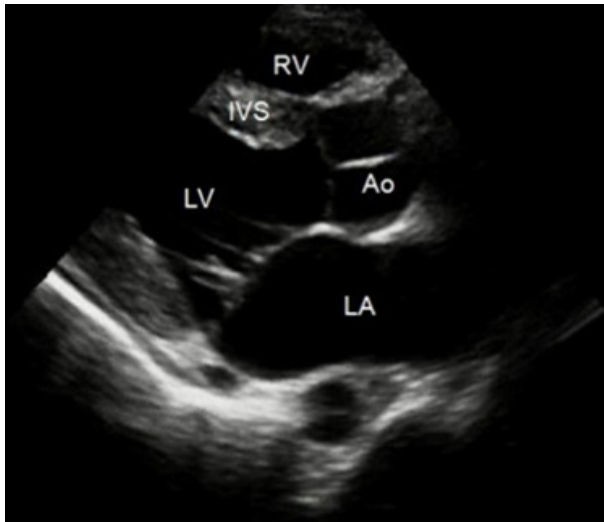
Post-chemotherapy transthoracic echocardiography in comparative view showed a markedly decrease in leukemic infiltration in all previous lesions.
